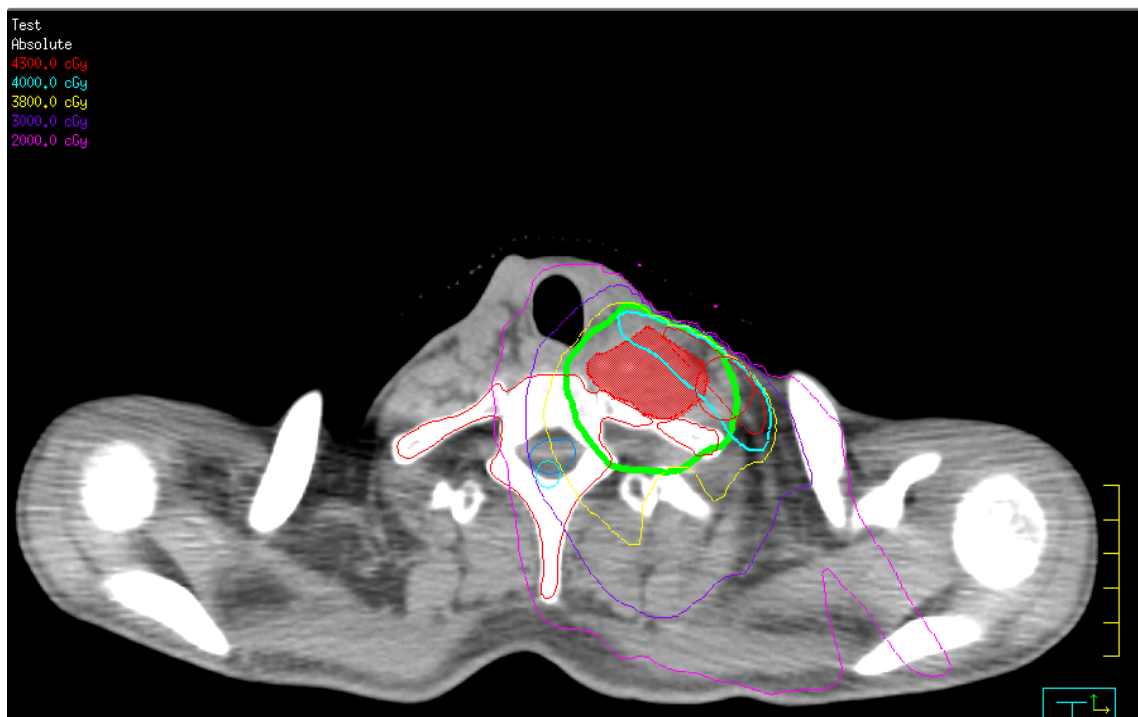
Case 1 daily CT with shoulder shifts. 40 Gy line (aqua) covers the same portion of CTV (red).
